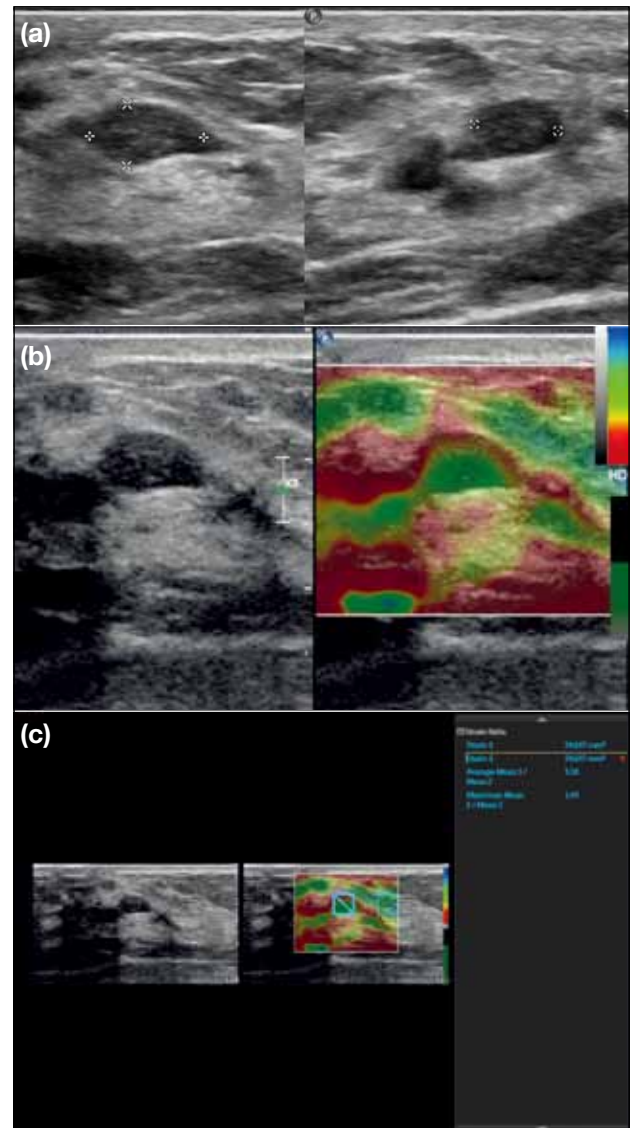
Fibroadenoma. (a) B-mode ultrasonography. An oval parallel hypoechoic nodule with circumscribed margin, Breast Imaging Reporting and Data System (BI-RADS) category 3 based on conventional B-mode ultrasound findings. (b) Strain elastography. The entire lesion was shaded in green, as was the variegated shading of green in the surrounding breast tissue. Elasticity score was 1. (c) Gland/lesion strain ratio was 1.38, lower than the optimal cut-off of 2.62 in our study. Modified BI-RADS category 3 was concluded based on the equation of $3 - 1 - 1 = 1$ (<3 was taken as 3), ie, modified BI-RADS category 3. Elastography parameters were in keeping with the benign pathology.
